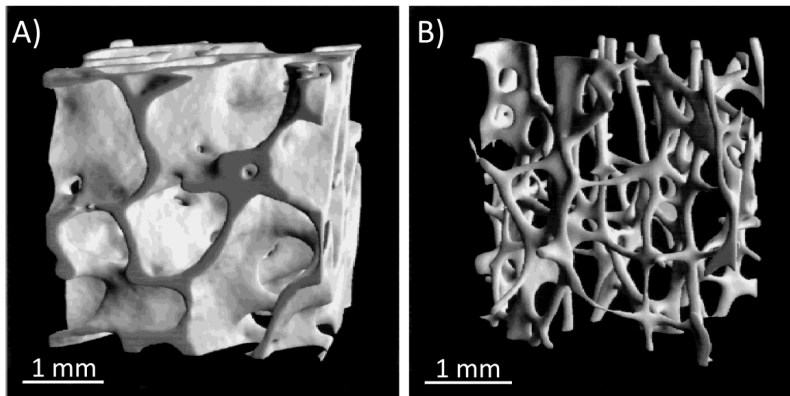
Reconstructed μ CT images of trabecular bone with mainly plate-like (femur head) A) and rod-like (lumbar spine) trabeculae B). (Adapted from [57], with permission of John Wiley & Sons.)
